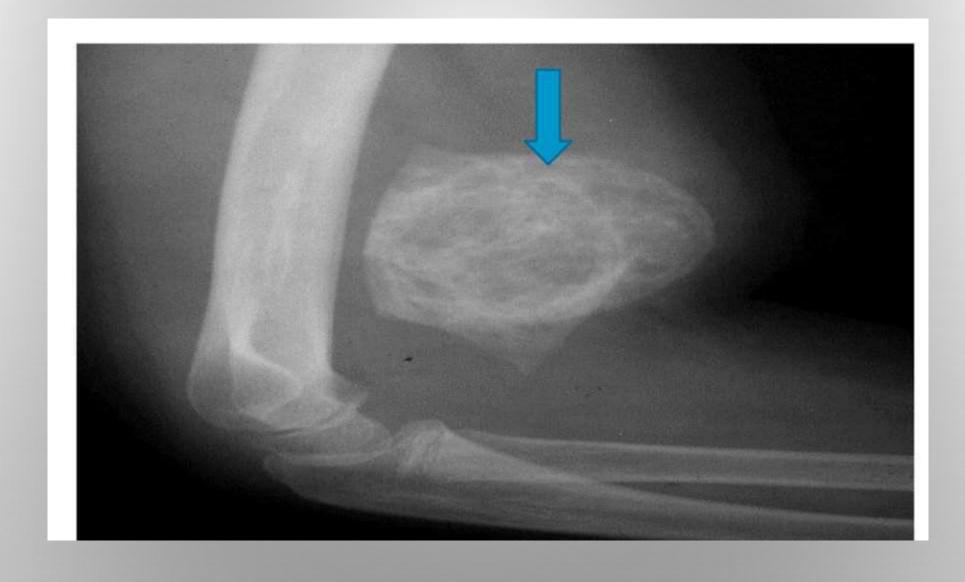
X-ray appearance of right arm showing myositis ossificans (arrow).
